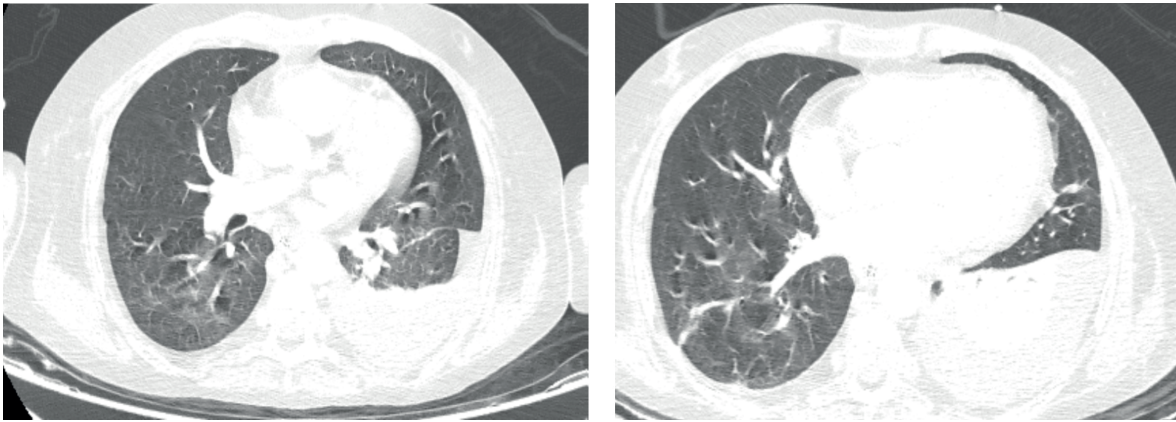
Computed tomography chest. Computed tomography of the chest demonstrates a cavitary nodule, pleural effusion, and atelectasis.
